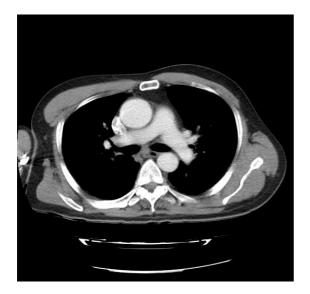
Contrasted CT image showing dilation of ascending aorta.
